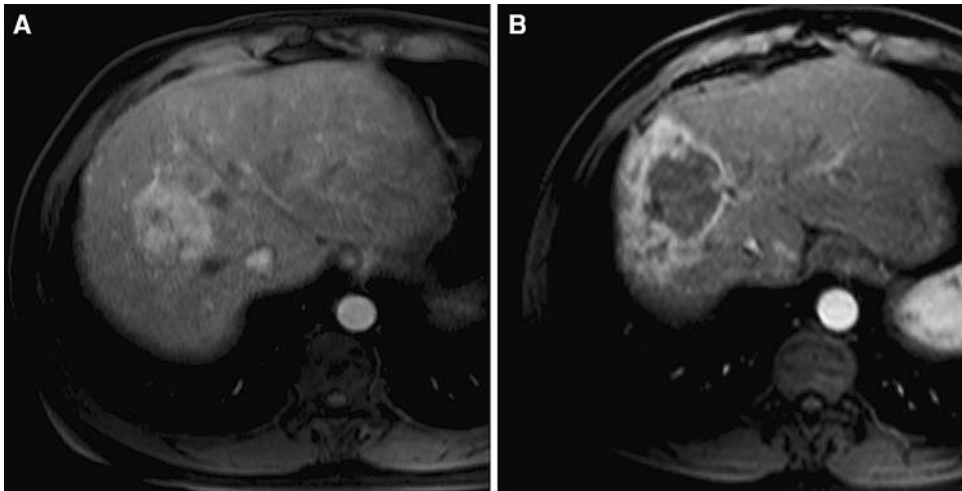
(A) T1-weighted contrast-enhanced MRI shows an arterially enhancing hepatoma in the right hepatic lobe. (B) Following Y90, T1-weighted gadolinium-enhanced MRI demonstrates tumor necrosis and surrounding hepatic parenchymal hyperenhancement from radiation occurring in a perivascular distribution.
